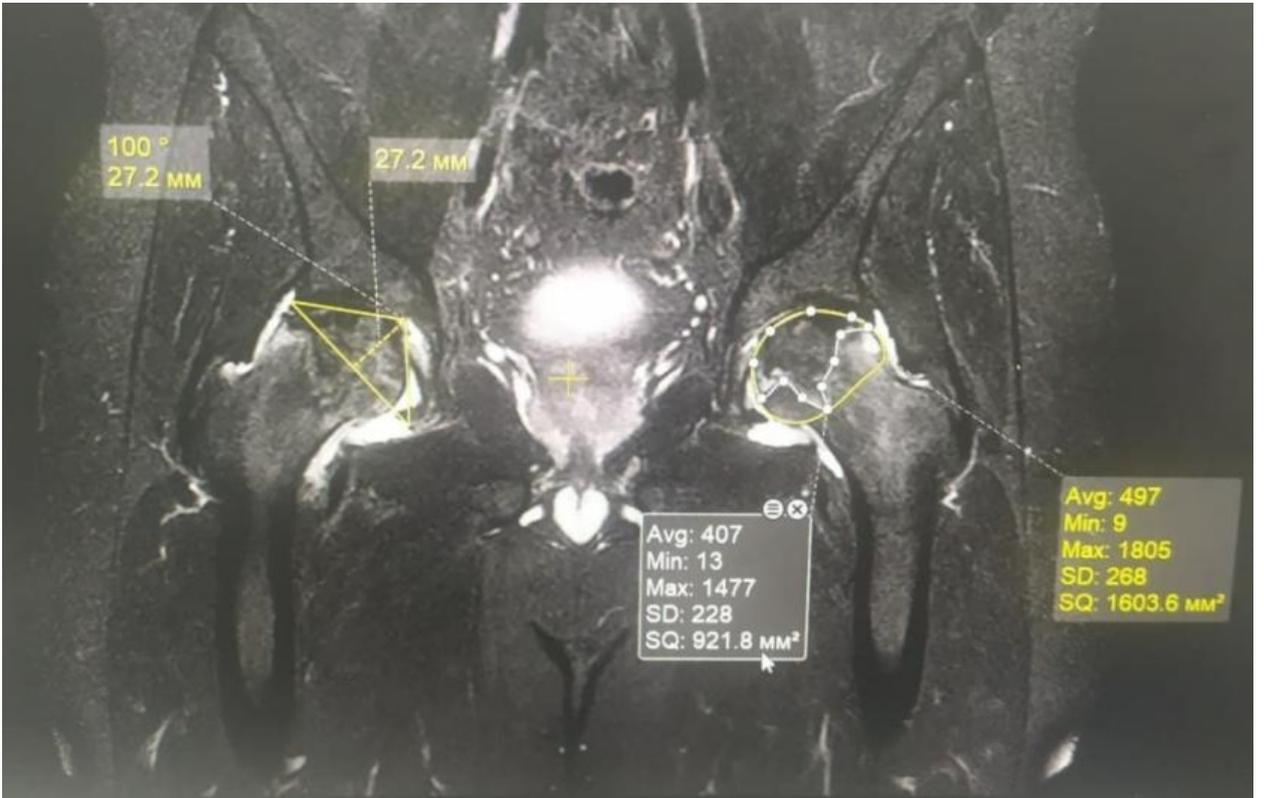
MRI of patient I.O. 1978 No. IB 3761/431 with stage II of ANFH disease before denervation.
